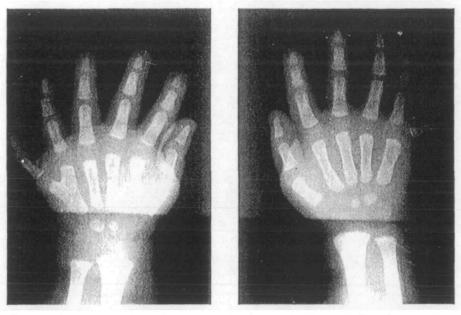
Radiograph of the hands of the newborn patient showing hexadactilia with fusion of 5th and 6th metacarpals of the left hand.
